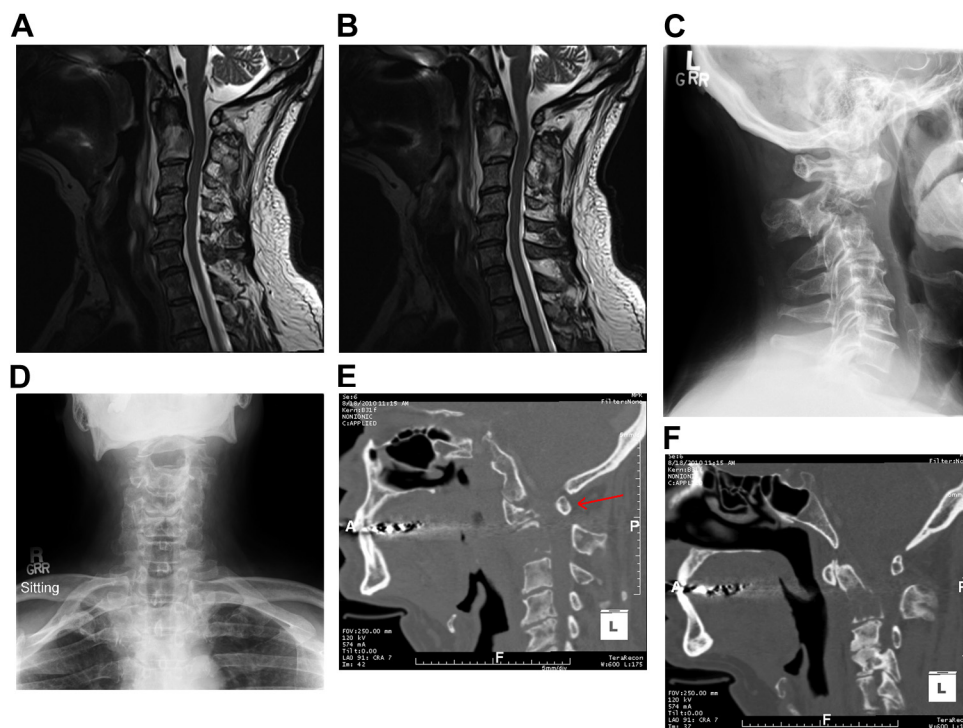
(A and B) T2-weighted sagittal magnetic resonance imaging after pathologic fracture of C2. (C and D) PA and lateral X-ray showing pathologic involvement of C2 with kyphosis. (E and F) Sagittal computed tomography reconstruction preoperatively displaying the anterior displacement of C1 ring to C2 with resultant cord compression. The red arrow indicates the anterior displacement of the C1 ring secondary to the kyphosis at C2. PA, Posterior Anterior.
